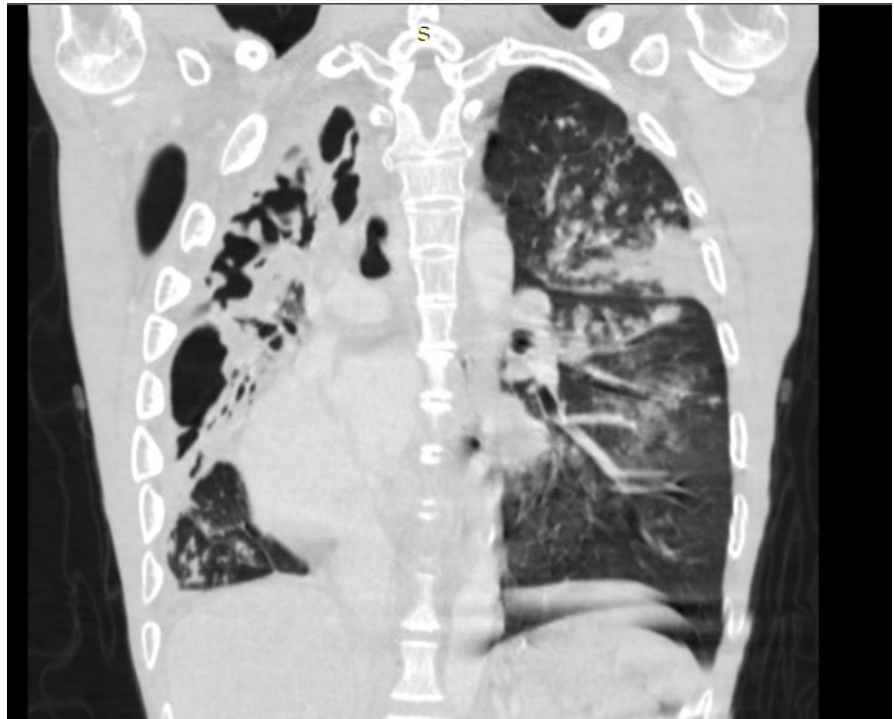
Chest CT-scan showing in parenchymal window the Parenchymal atelectasis on the right.
